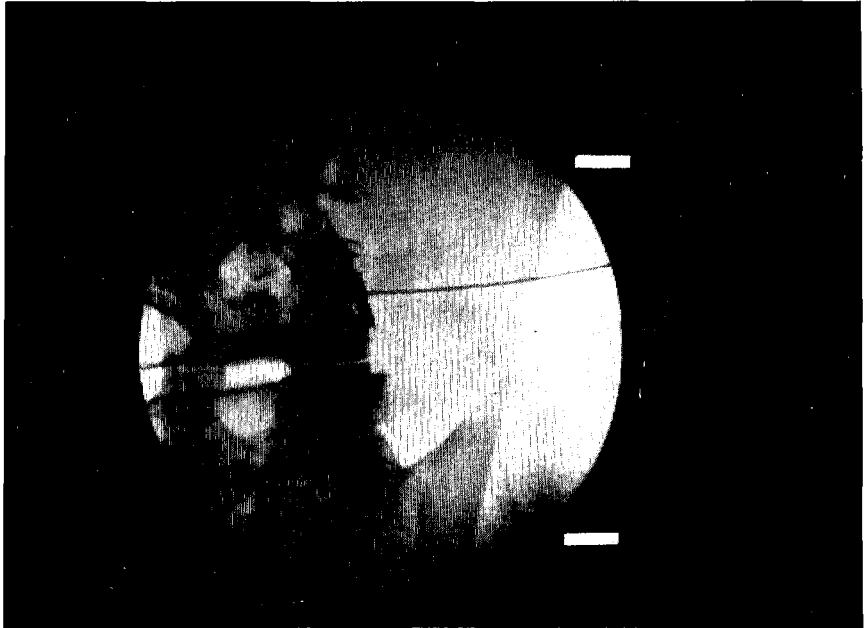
X-ray; AP view + contrast
